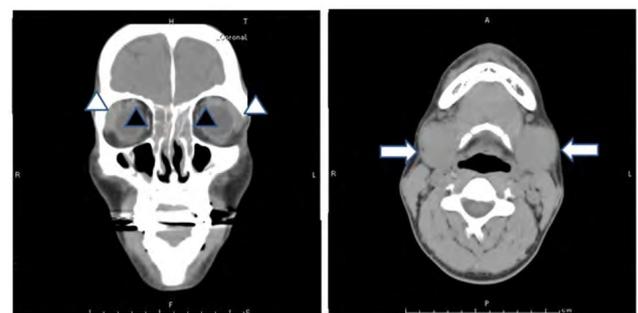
Computed Tomography (CT) of the paranasal sinuses and neck revealed bilateral sinusitis (black arrow heads), lacrimal gland swelling (white arrow heads) and bilateral submandibular glands (white arrows).
